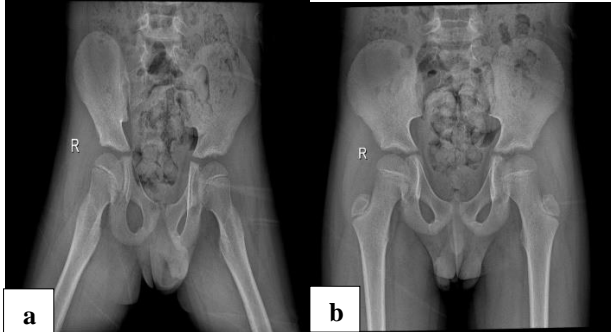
(a) and (b) X-ray hip (B/L)- frog leg view and X-ray pelvis – AP.
